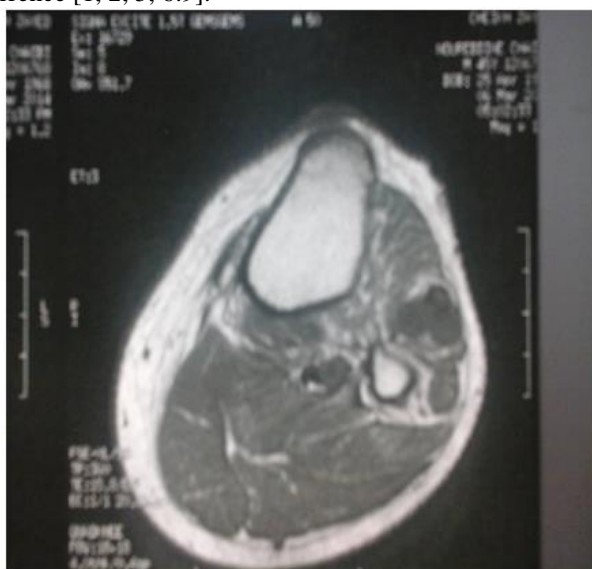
Cross-sectional weighted T1 MRI showing a multi-celled training, signal hypointense
